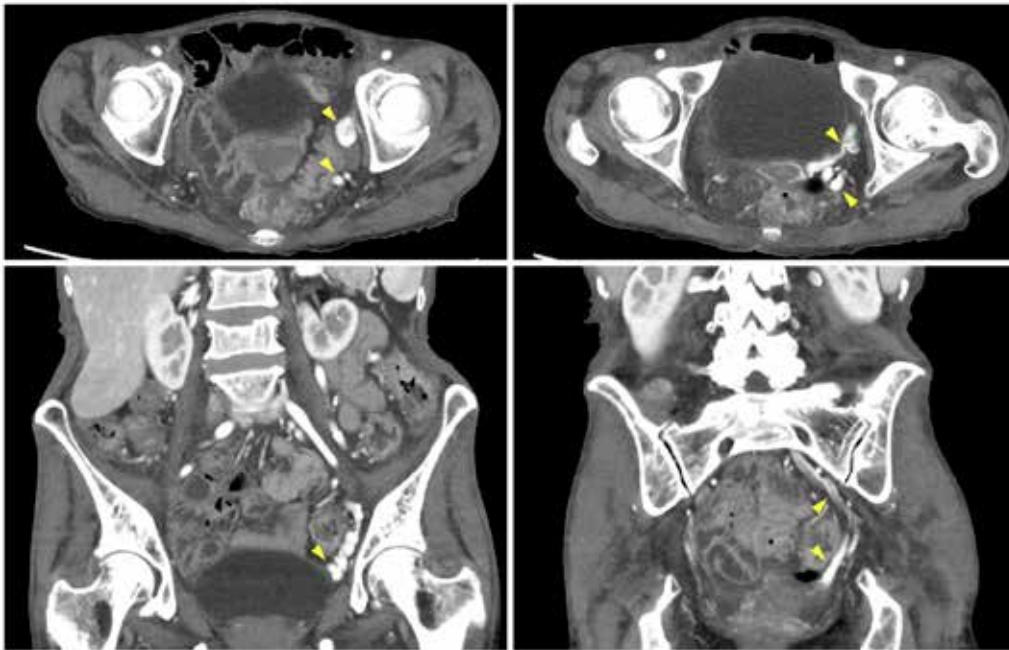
Computed tomography (CT) shows that strong edema and peripheral wall thickening from the sigmoid colon to rectum. Yellow arrowheads point to the intestinal arteriovenous malformations and vasodilation. This sign is called “comb sign”.
